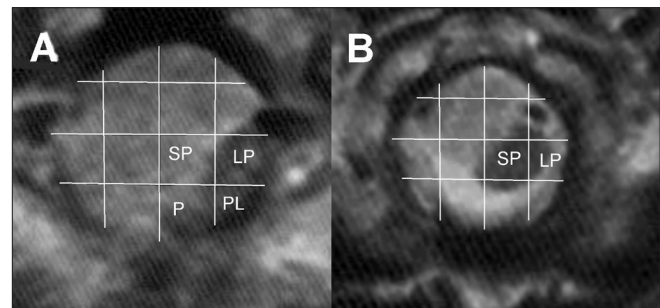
Schemes of spinal cord compression and displacement according to axial MRI sections of the tumor at C1–C2 level. (a) Axial MRI at C1 level (spinal cord displaced to LP, PL, P sectors) and (b) axial MRI at C2 level (spinal cord displaced to LP, SP sectors)
